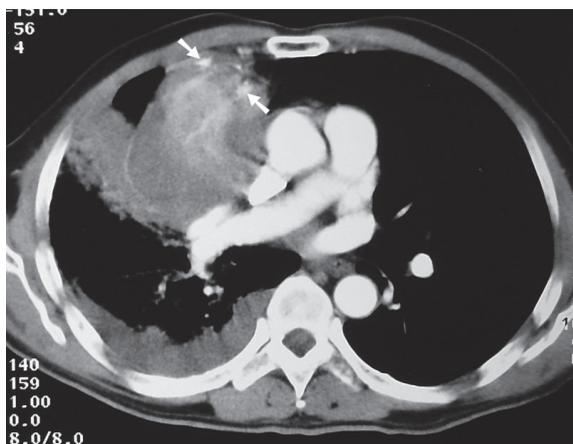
Contrast-enhanced CT: Pathological vessels and contrasting hemorrhagic foci (small arrows) are seen within the mass.
